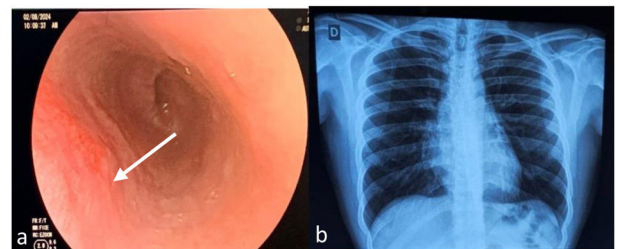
a) Area of linear erythema in the left wall of the mid-to-distal esophagus; b) Normal chest x-ray.
